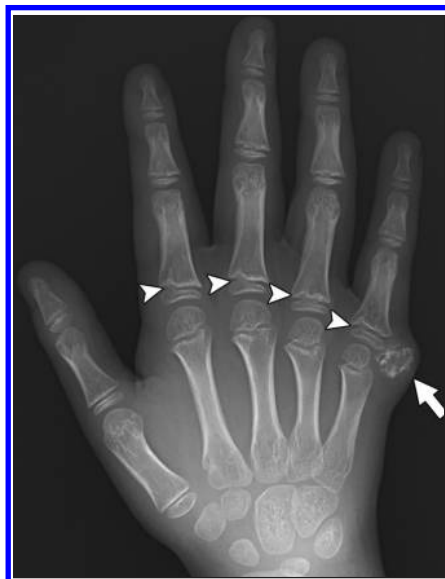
9-year-old boy with palpable mass. Posteroanterior radiograph of right hand shows lobular calcified subcutaneous mass near right fifth metacarpophalangeal joint (*arrow*) as well as diffusely abnormal shape of metaphyses of proximal and middle phalanges and metacarpals of both hands, with large cartilage tongues extending into metaphyses of proximal phalanges (*arrowheads*). Taken together, these findings are most indicative of metachondromatosis, for which patient had genetic testing that confirmed diagnosis.
